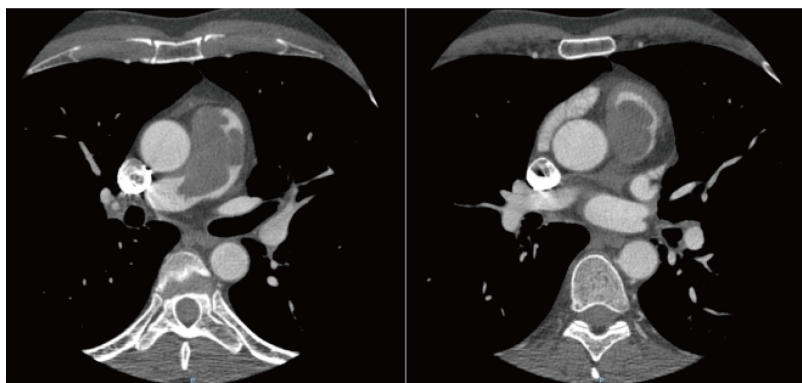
Angio-computed tomography: Filling defect in pulmonary artery trunk measuring 58 mm × 32 mm × 44 mm, extending from the subvalvular area to the origin of the right pulmonary artery.
